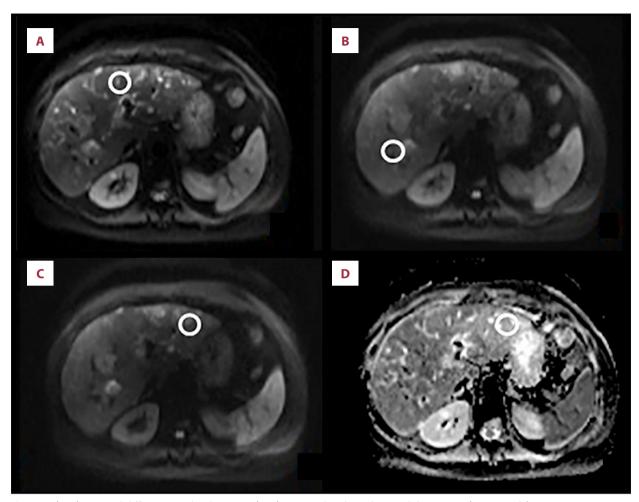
(A-D) MR axial diffusion-weighted imaging (DWI) scans. Dilated intrahepatic biliary tracts (empty circle).
